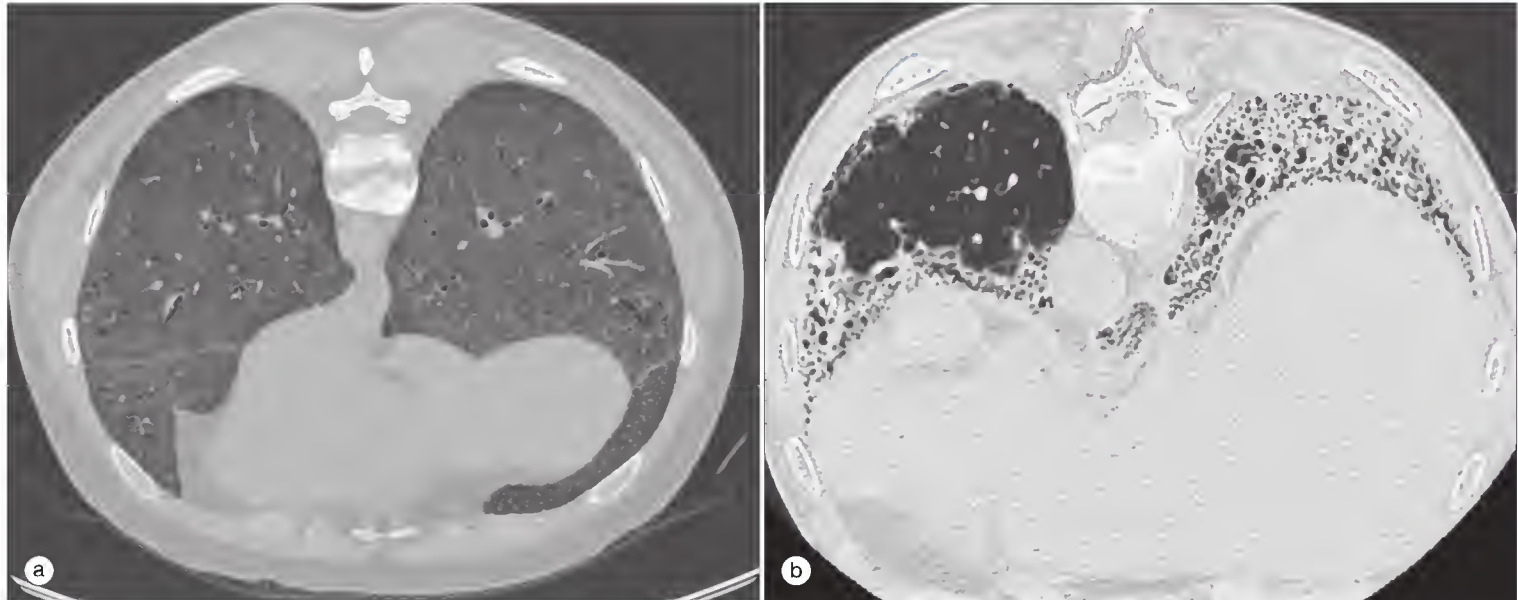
Pattern of interstitial change in systemic sclerosis (SSc)—associated lung disease—utility of high-resolution computed tomography (HRCT). (a) Ground-glass appearance. Amorphous shadowing is present throughout the lung parenchyma in this representative slice of HRCT in a patient with early diffuse SSc. It can be difficult to differentiate inflammation from fine fibrosis, and so this appearance cannot be regarded as synonymous with alveolitis. In later established disease there may be traction bronchiectasis and other features that allow fibrosis to be determined with confidence. Extent of involvement appears to be more important than pattern of abnormality in predicting likelihood of progression. Pattern of change does not predict responsiveness to immunosuppression. (b) Reticular honeycomb appearance. Established fibrosis is associated with a typical coarse reticular pattern of abnormality. Biopsy studies confirmed that there may be inflammatory foci within this tissue, and so some reversibility is possible. As with other appearances in SSc, lung fibrosis extent is more important than pattern of abnormality in predicting outcome.
